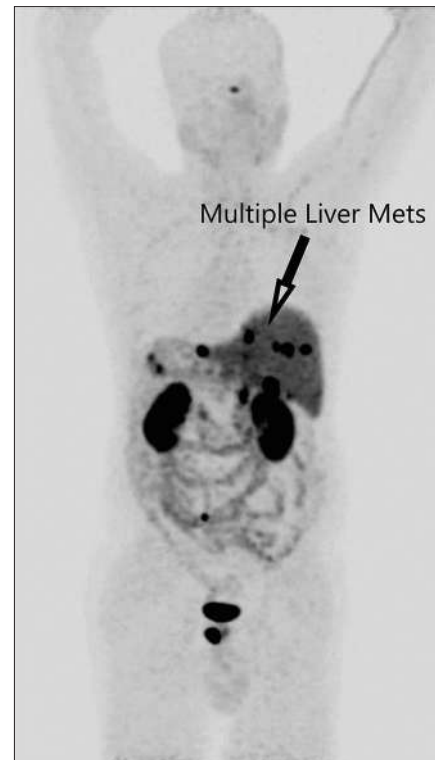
^{68}Ga -DOTATATE PET CT study of the same gentleman at the end of chemotherapy with uptake in multiple liver lesions and left pubic bone - progression. Posterior view
